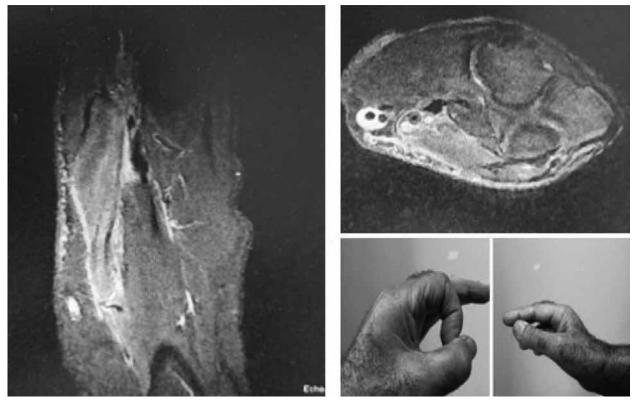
Edema at the level of the pronator teres and flexor carpi radialis muscles and flexion weakness in the fingers in the axial and coronal sections of the right elbow (MRI of Case 2)
